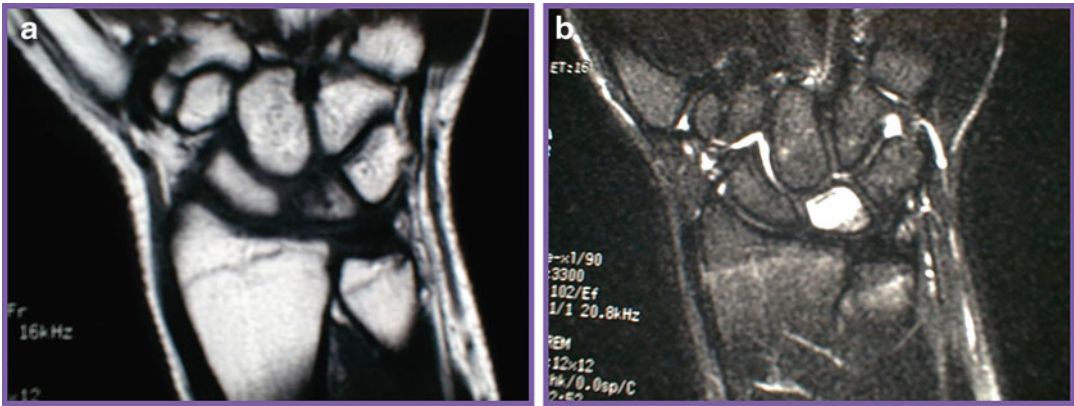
MRI sequences before immobilization. (a) T1-weighted sequence shows decreased signal intensity within the lunate, centered on the radial aspect. (b) Markedly increased signal in the lunate on T2
